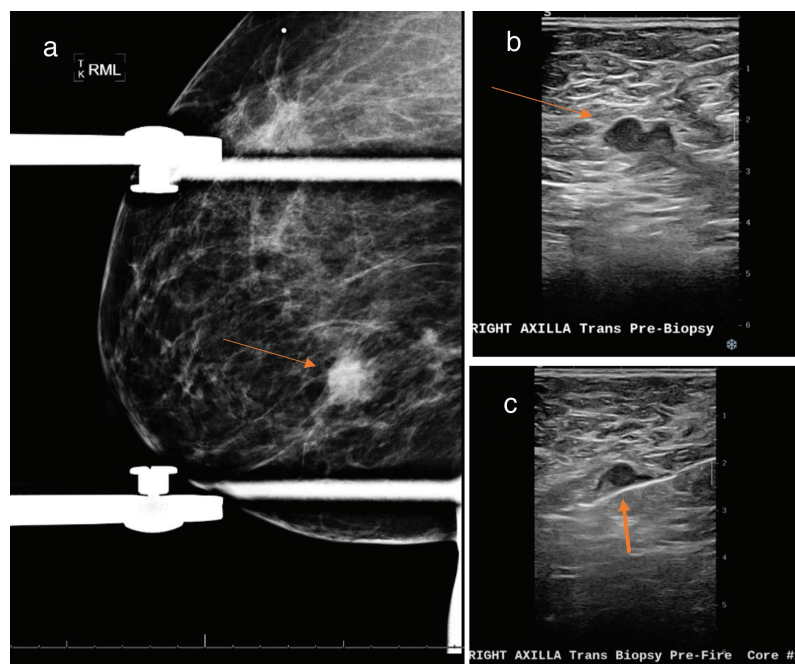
A 34-year-old woman with right breast cancer (a), 2.5 cm, with a single metastatic axillary adenopathy identified with axillary ultrasound (b), and needle biopsy (c). Anatomic T2N1M0, Stage IIA (AJCC 7th edition).
